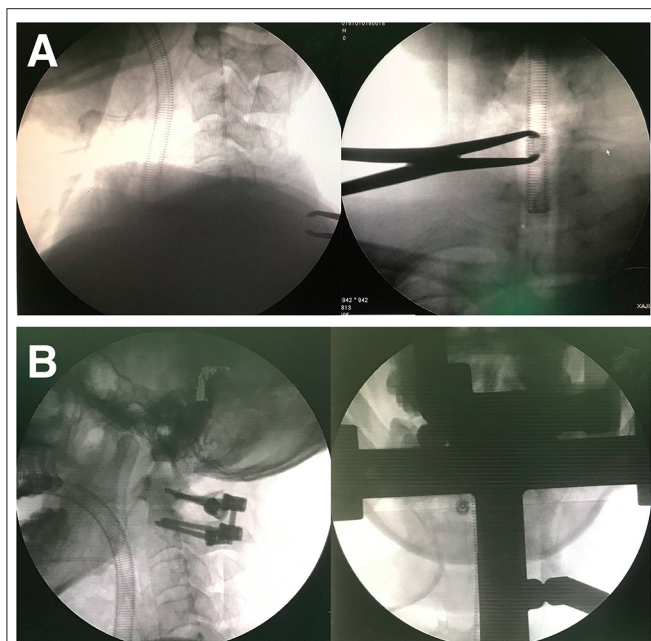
Anterior-posterior intra-operation radiography is available in BSPST position benefit from X-ray penetrable characteristics of plaster (A,B).
